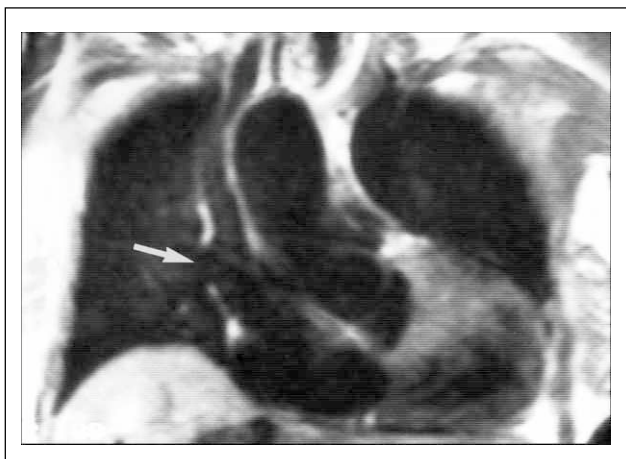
Coronal T1-weighted sections delineates the anomalous drainage of the pulmonary veins into the superior vena cava
